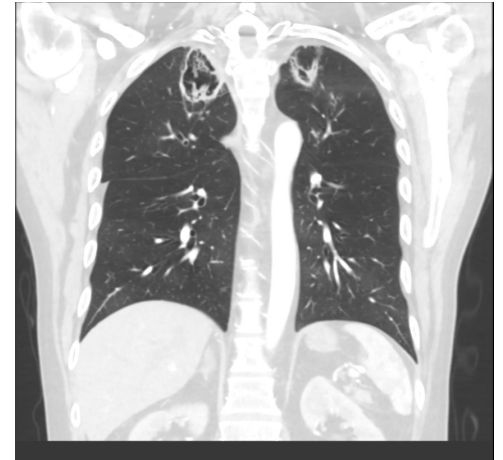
Coronal view CT
